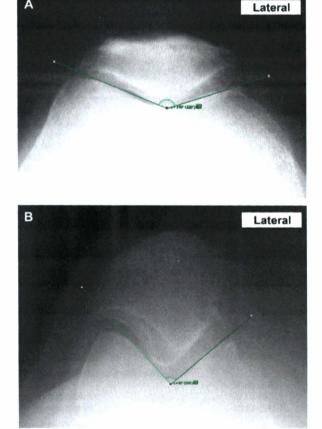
Skyline radiographs used to measure femoral sulcus angle. The femoral sulcus angle was defined by lines joining the highest points of the medial and lateral condyles and the lowest point of the intercondylar sulcus as previously described^{17,18}. (A) Shows a shallow and (B) a narrow sulcus angle.
